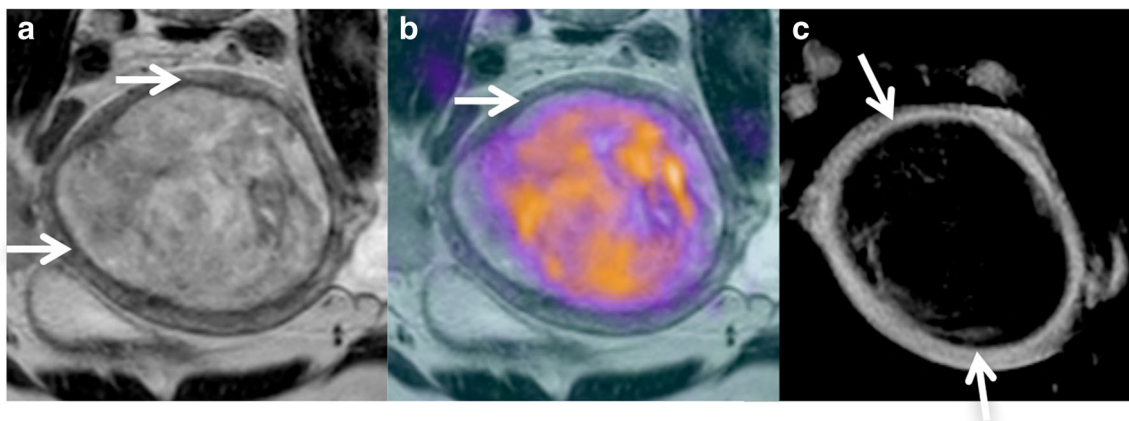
a and b. Axial-oblique T2WI (a) and fused axial oblique T2-DWI (b) show a large tumor distending the endometrial cavity (white arrows) and compressing the myometrium; a continuous low signal intensity
